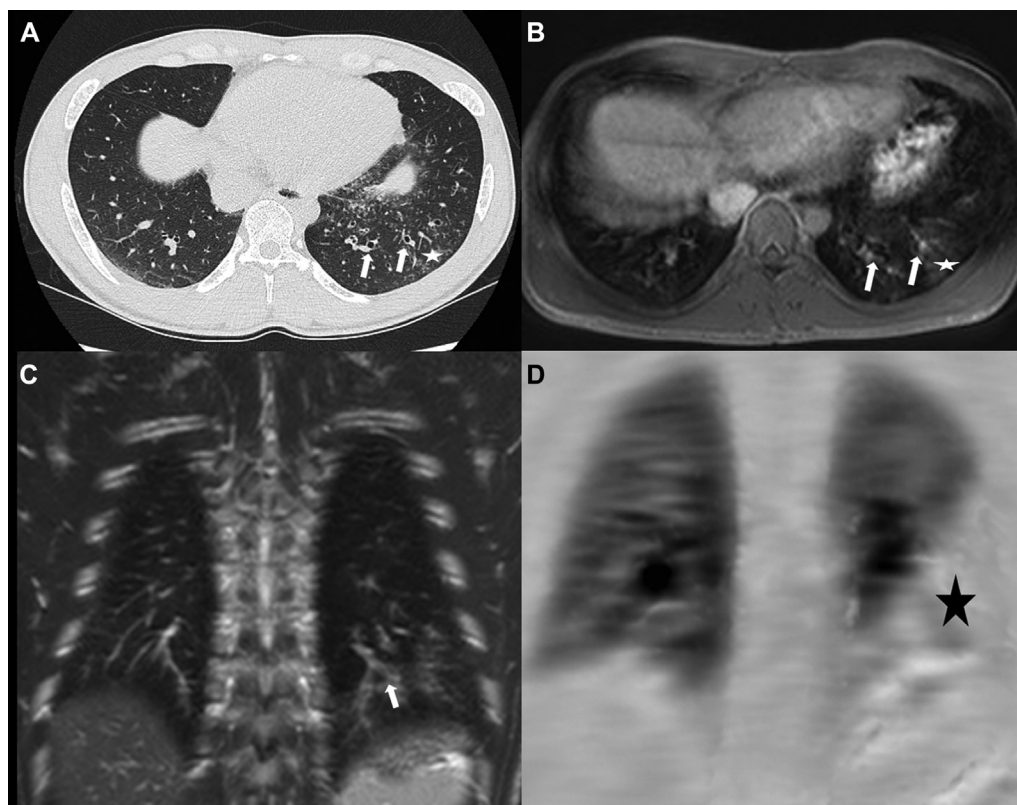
Lung abnormalities on MRI and HRCT images of a 35-year-old male patient with CHH. A male patient aged 35 years with bronchiectasis (white arrows) and mucous plugging (white asterisks) in the left lower lobe on axial HRCT slice (A) and MRI (B, Axial gadolinium-enhanced T1-weighted gradient-echo sequence; C, coronal breath-hold Single Shot Turbo Spin Echo). With gadolinium-enhanced dynamic perfusion T1-weighted sequence (D), hypoperfusion of the left lower lobe (black asterisk) was observed.
